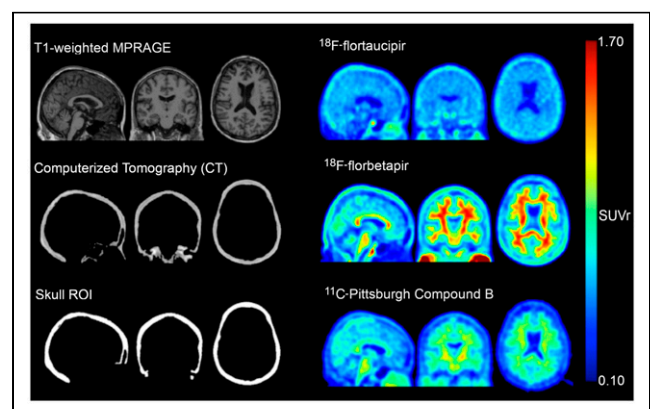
MR, CT, and SUVr images from amyloid-negative participant with high skull binding in all 3 radiotracers. Images are in MNI-152 space. MPRAGE = magnetization-prepared rapid acquisition with gradient echo.
